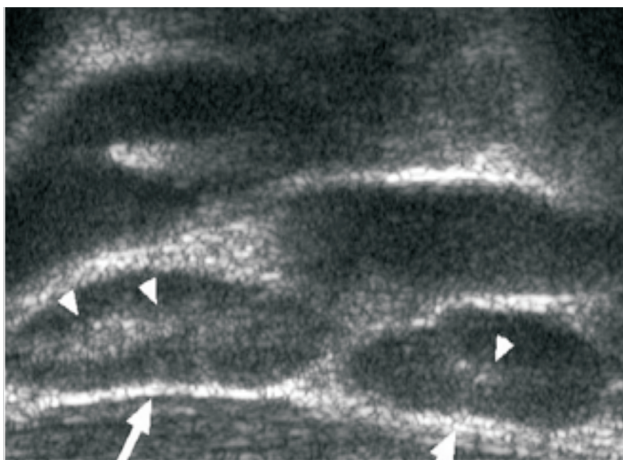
Typical reactive node: Sonographic appearance of lymph nodes benign oval shape lymph node with hypo-echoic cortex peripherally (black)
